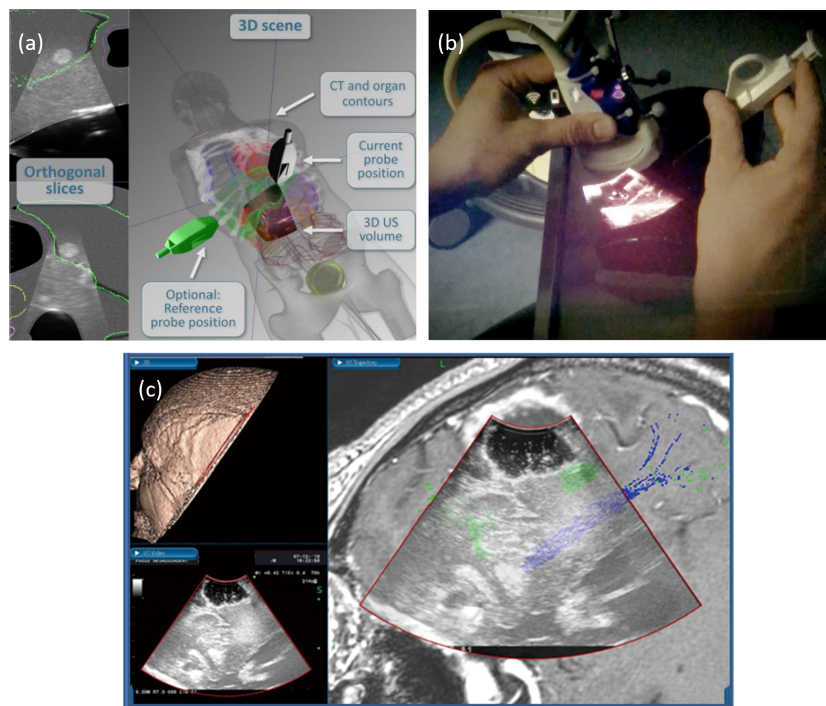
Examples of US guidance in therapeutic applications. (a) Guidance system to facilitate US probe placement in radiotherapy. The spatially tracked probe and the US volume are visualized with respect to a previously acquired CT and segmented organs (Copyright © [2018] IEEE. Reprinted with permission from [37]). (b) In-situ visualization of a 2D US image to guide needle placements (Figure by C. Rüger et al. [38] under CC-BY license). (c) Intraoperative US image overlaid on preoperative MRI image, including subcortical association fibers for neuronavigation (Figure by M. Ganau et al. [39] under CC-BY license).
